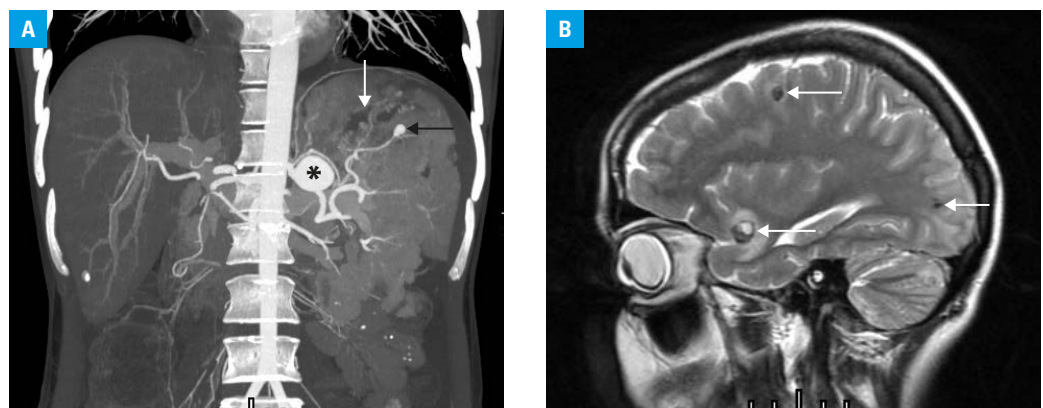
A – computed tomography scan of the abdominal cavity with contrast enhancement showing splenic artery aneurysm (asterisk), small mycotic aneurysm of a small branch of the splenic artery (black arrow), and irregular splenic hematoma (white arrow); B – magnetic resonance imaging of the brain (T2-weighted image) showing mycotic hematomas (arrows); due to their small size (early stage), the changes did not exhibit a typical profile of fungal granulomas, which are characteristic of larger lesions.
